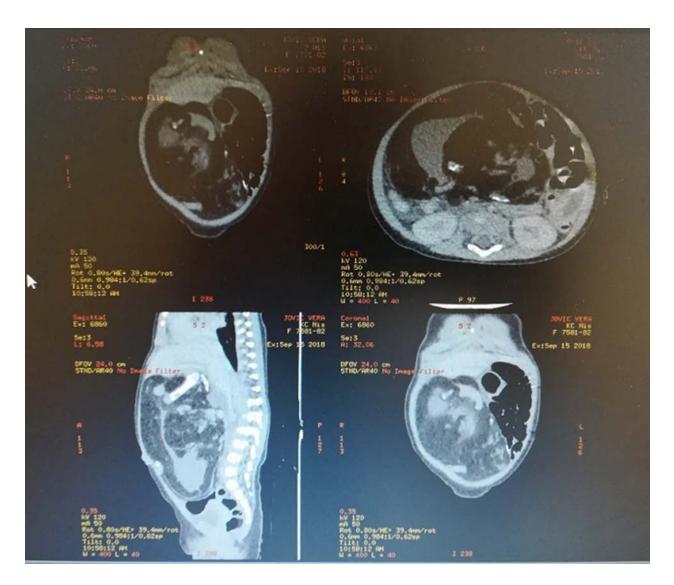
Computed tomogrphy (CT) scans revealed a large tumor within the right hemiabdomen
